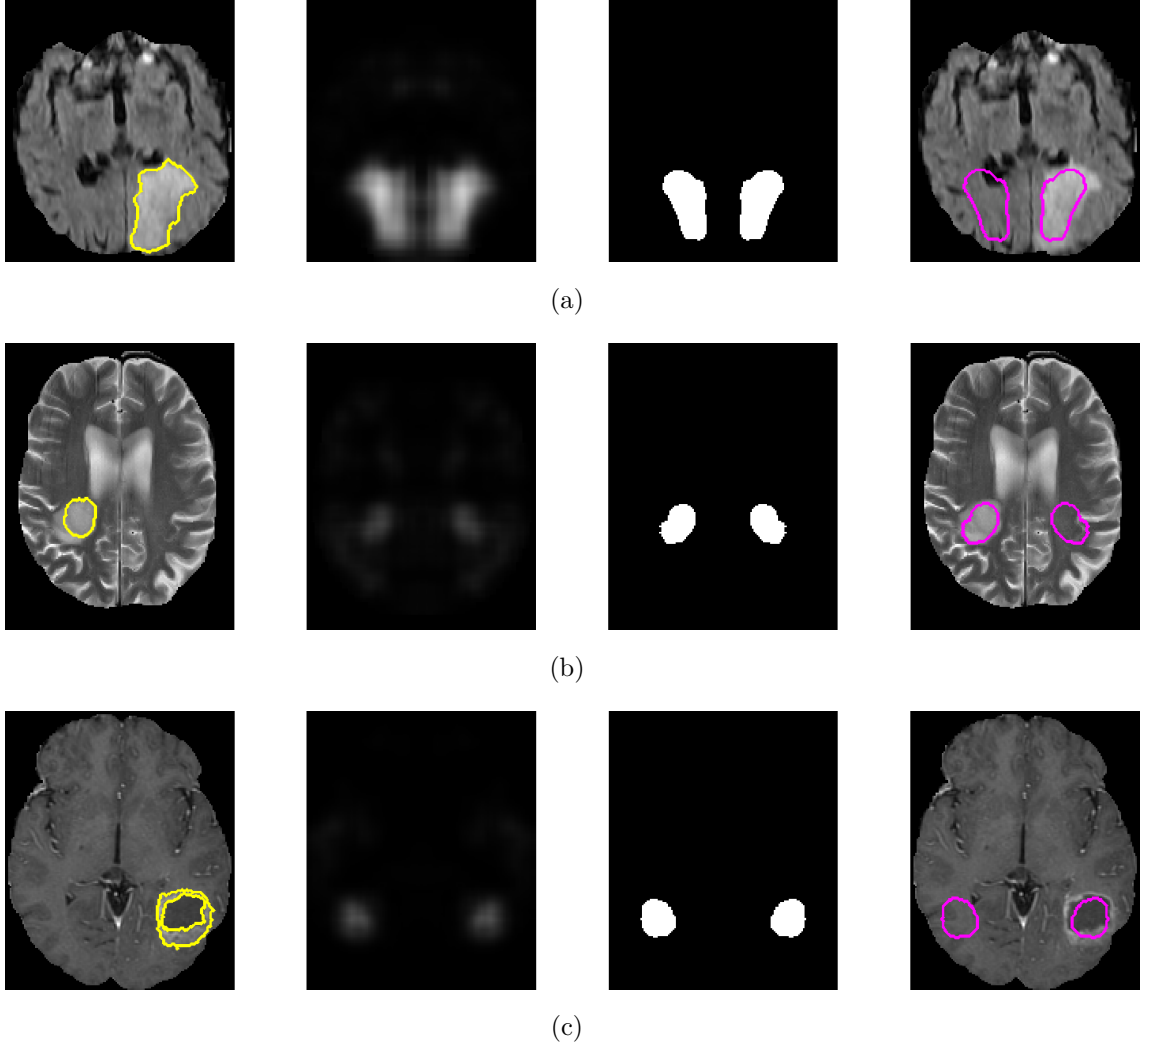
Examples of thresholding multiresolution maps by absolute values. From left to right: input axial slice with manual annotation ((a) whole tumor, (b) tumor core, (c) active tumor), multiresolution asymmetry map, binary mask after thresholding, application of the resulting mask to the input image. (a) input image: FLAIR, threshold: 0.2, (b) input image: T2, threshold: 0.05, (c) input image: T1C, threshold: 0.05.
